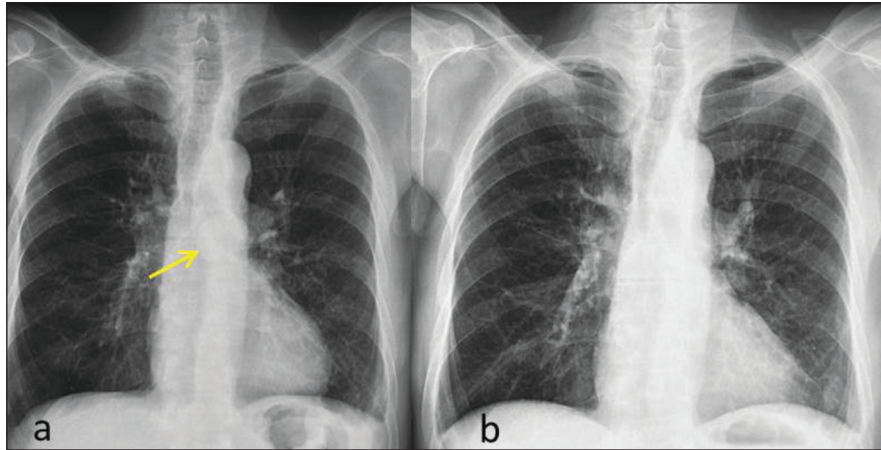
Preoperative chest X-ray revealed a mass superpoze to the mediastinum (white arrow) (a). Normal chest X-ray findings on 11th postoperative day (b).
